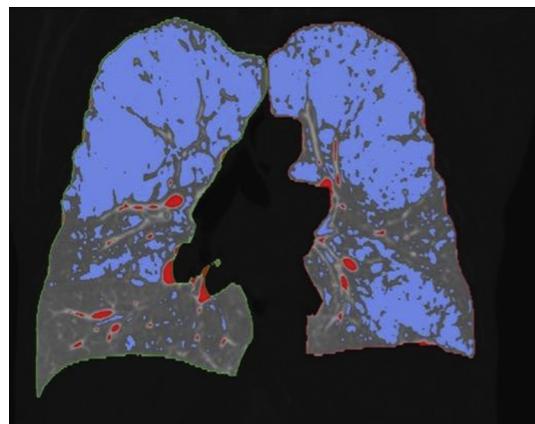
Emphysema quantification software Syngo. CT Pulmo 3-D. Color blue corresponds to regions of emphysema (-950 HU). (Courtesy of Siemens Healthcare GmbH, Erlangen, Germany.)
